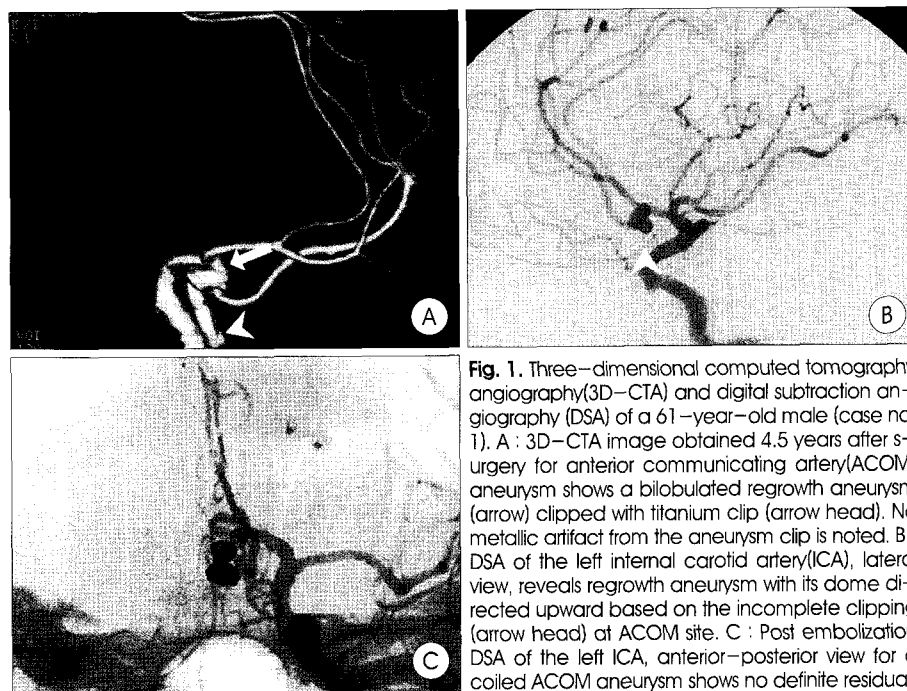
Three-dimensional computed tomography angiography(3D-CTA) and digital subtraction angiography (DSA) of a 61-year-old male (case no. 1). A : 3D-CTA image obtained 4.5 years after surgery for anterior communicating artery(ACOM) aneurysm shows a bilobulated regrowth aneurysm (arrow) clipped with titanium clip (arrow head). No metallic artifact from the aneurysm clip is noted. B : DSA of the left internal carotid artery(ICA), lateral view, reveals regrowth aneurysm with its dome directed upward based on the incomplete clipping (arrow head) at ACOM site. C : Post embolization DSA of the left ICA, anterior-posterior view for a coiled ACOM aneurysm shows no definite residual.
